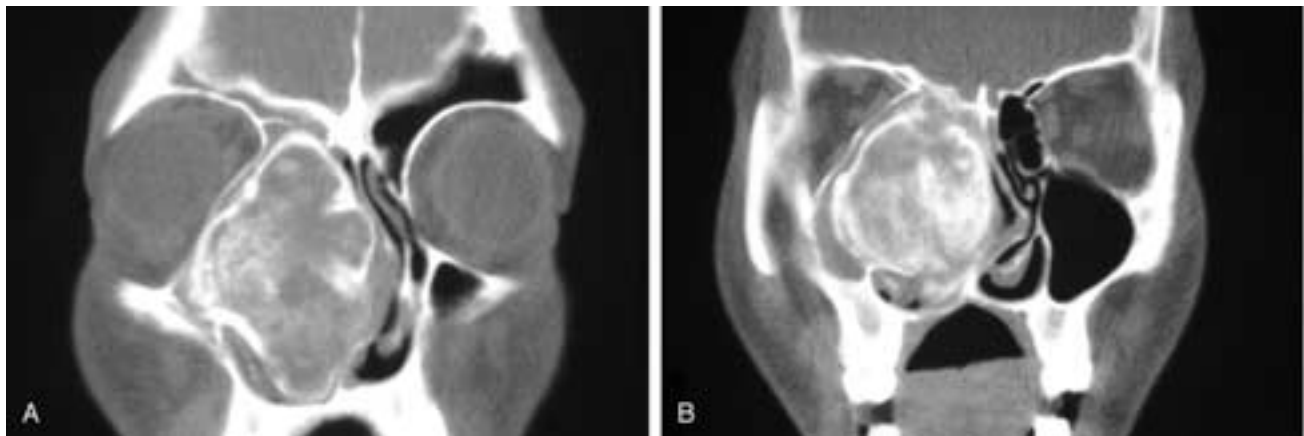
Coronal CT scans (A and B) show an ovoid expansile mass projecting into the right nasal fossa and the right ethmoid and maxillary sinuses. Obstructed secretions are present in the remaining right antrum. Surrounding the partially ossified mass is a cortex. This patient had an ossifying fibroma.
